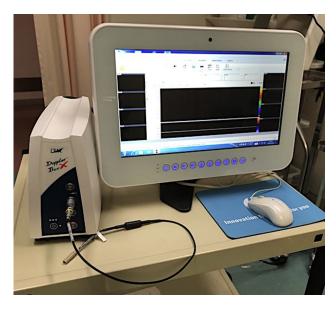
Doppler probe ultrasonography system with Doppler probe (Doppler-BOX and monitor, 16-MHz pulse-wave). Printed with permission from Compumedics, Inc.
